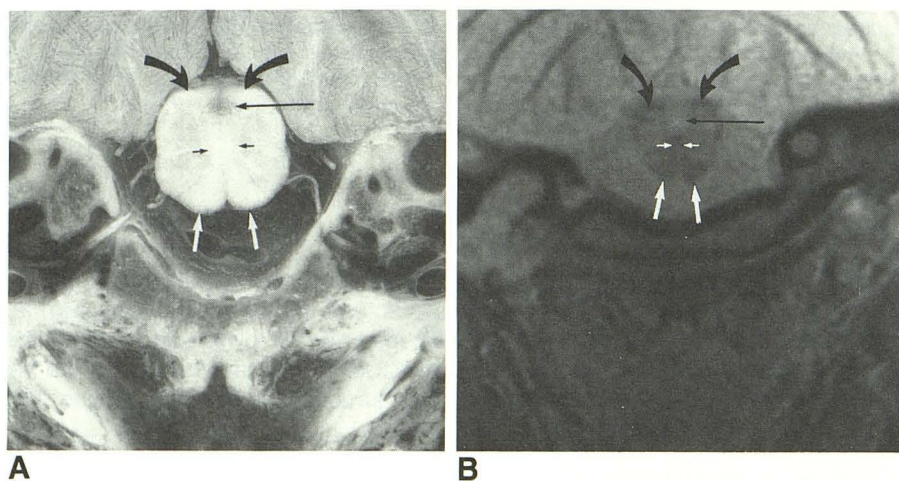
Anatomic and MR sections at level 2. Cryomicrotomic section (A), SE 800/20 MR image (B). The pyramidal tracts (large white arrows), medial lemniscus (small arrows), nucleus gracilis and cuneatus (curved arrows), and central gray matter (long thin arrows) are seen. Anterolateral to medial lemniscus are the inferior olivary nuclei.
